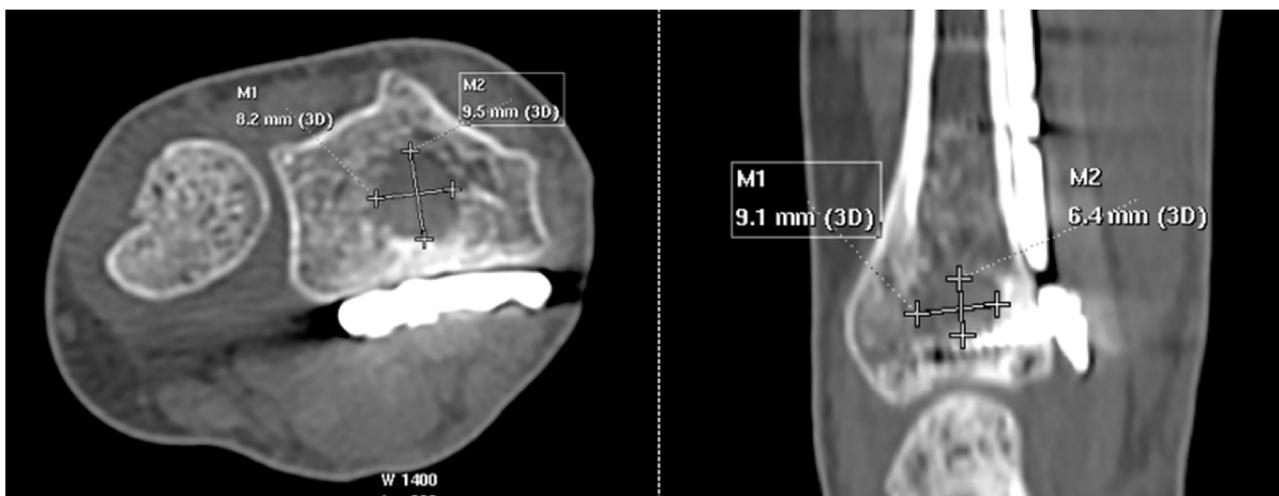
Example of the measurements done on the axial slices (left) and sagittal slices (right) to calculate the volume of the residual metaphyseal defect on the CT scan at 6 months post-operative. On the axial slice (left image), this defect was 8.2 mm wide and 9.5 mm thick. On the sagittal slice (right image), this defect was 6.4 mm tall and 9.1 mm wide.
